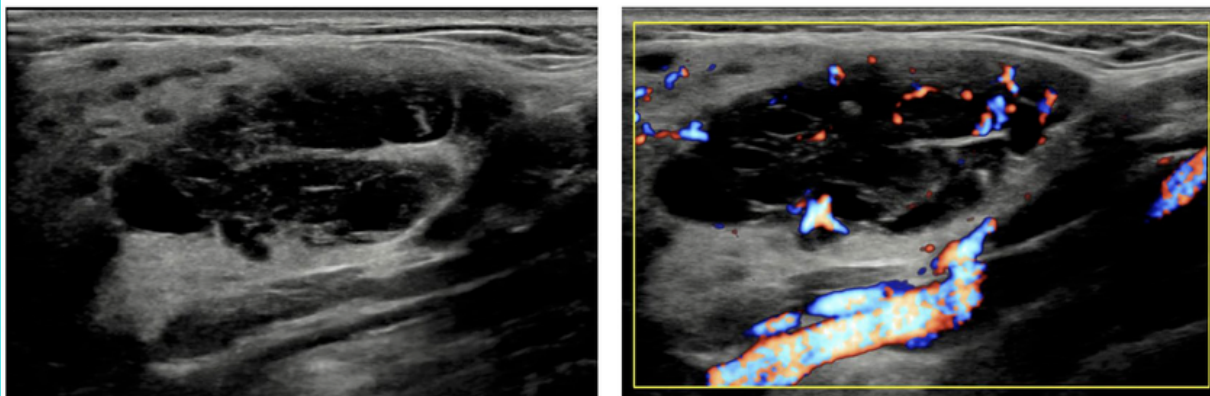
Ultrasonographic features of a parotid gland focal lesion in a patient with Sjögren's disease complicated by MALT lymphoma. The lesion appears as a polylobulated, hypoechoic area, clearly demarcated from the surrounding inhomogeneous parenchyma; it is also characterized by internal septa and intralesional vascularization.
